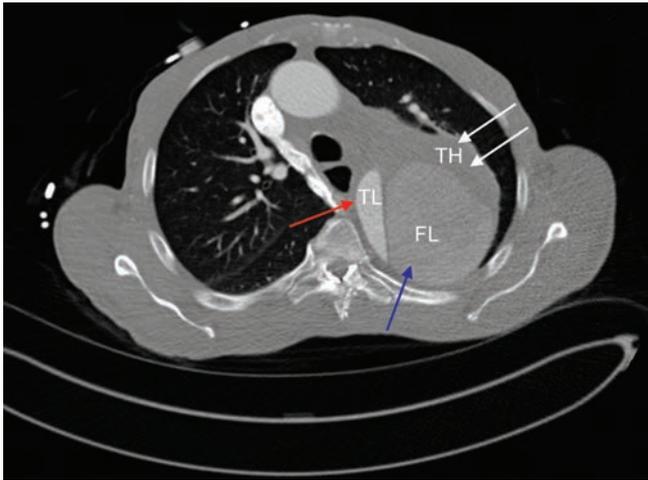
Axial plane of CTA revealing a small true lumen (red arrow), a large false lumen (purple arrow) and a large burden of thrombus (two white arrows).
